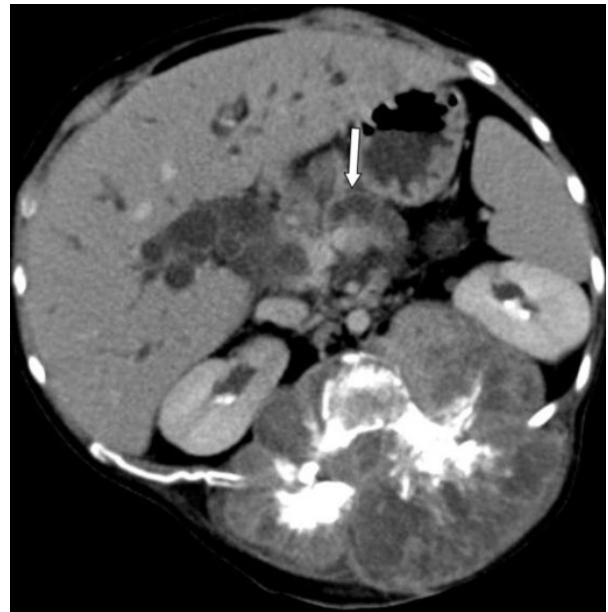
On abdominal CT the pancreatic canal was dilated (arrow).
